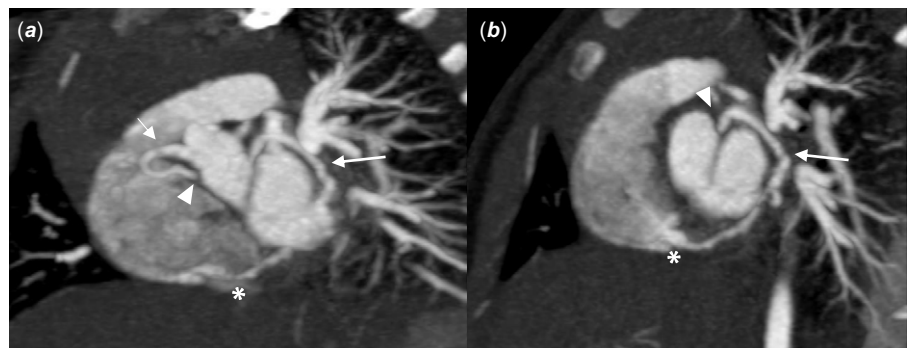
CT angiography reconstructed images (maximum intensity projection), coronal (a) and sagittal (b) oblique planes. Images depict the dilated right coronary artery at the origin in the right coronary sinus (short arrows) with retroaortic course (arrowheads), continuing in the left atrioventricular groove (long arrows) and entering the right ventricle (*).
